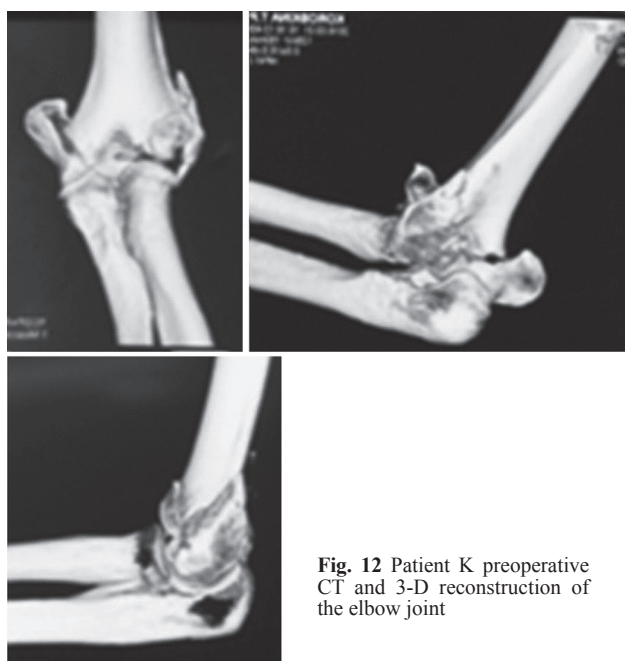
Patient K preoperative CT and 3-D reconstruction of the elbow joint
